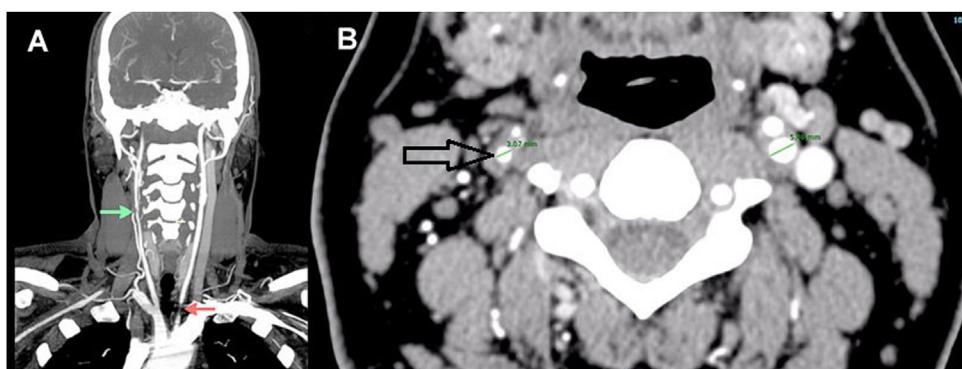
Computed tomography angiography (CTA), coronal view demonstrated focal stenosis in the right common carotid artery (CCA) (Green arrow) and near occlusion of the proximal left CCA. (Red arrow) (A). Axial view shows focal stenosis in the right internal carotid artery (ICA) (Black hollow arrow) (B).
